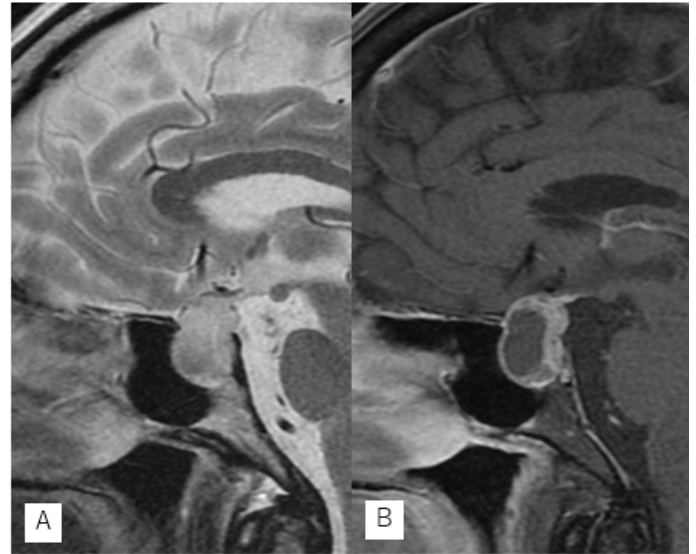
Magnetic resonance imaging brain showing a cystic mass in the sella.
